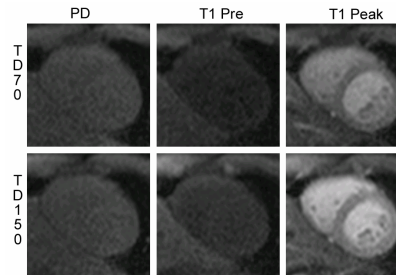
Example images show that the T1-weighted images of TD150 study has visually better SNR than the TD70 (window and level the same). The proton density reference image used the same parameters and thus similar SNR.
